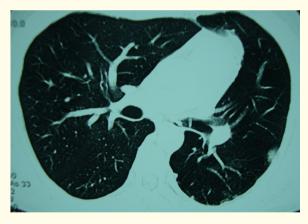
Contrast-enhanced thoracic CT revealing some small bronchiectases filled with mucus and left hilar lymph nodes.
